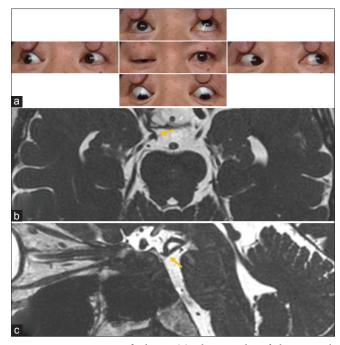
Preoperative findings. (a) Photographs of the patient's eyes showing right blepharoptosis and moderate supraduction. Adduction and infraduction are not clearly observed. Her right pupil is not dilated. (b and c) Preoperative axial (b) and sagittal (c) heavily T2-weighted magnetic resonance images demonstrating the right posterior cerebral artery bent caudally and apparently conflicting with the right oculomotor nerve.
